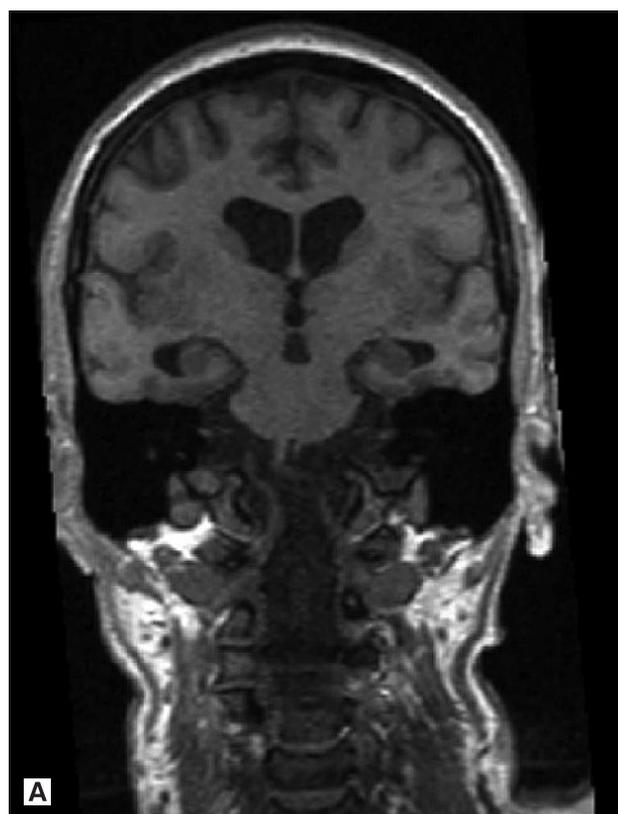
Brain MRI. T1-weighted, coronal: perisylvian polymicrogyria is seen bilaterally (A). T1-weighted, sagittal: volume of parietal and temporal lobes are bilaterally more significantly decreased than in other lobes (B).
